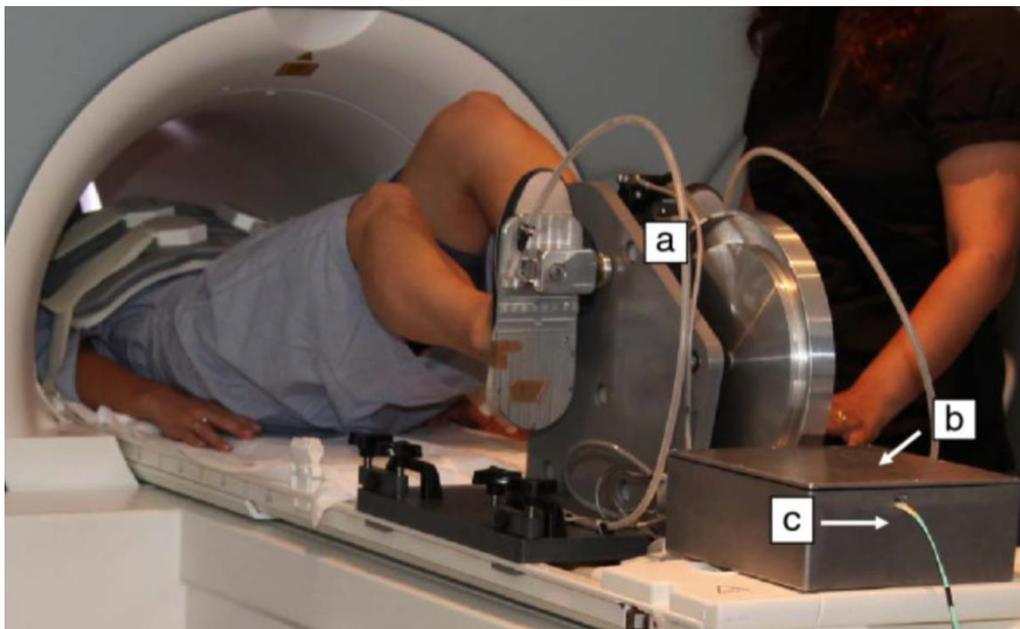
MRI cycle ergometer setting with: (a) cycle ergometer, (b) electronic box, and (c) optical fibre line (Gusso et al., 2012).
